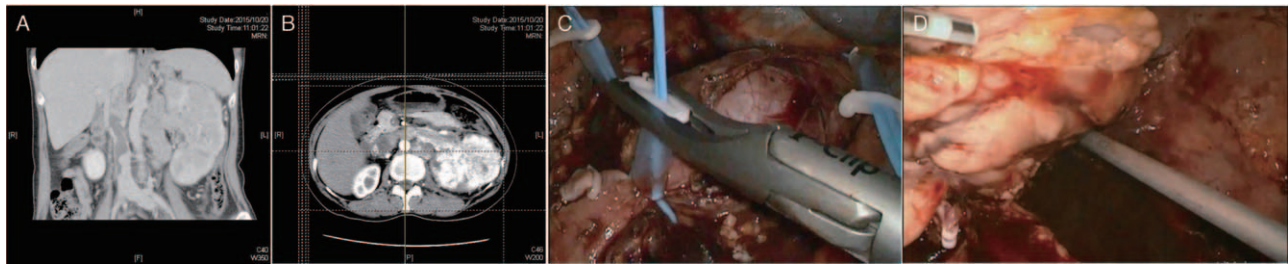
Plain computed tomography showing left kidney carcinoma with inferior vena caval thrombosis (A). The tumor and thrombus (coronal section; B). Isolating the vena cava and exposing the vena caval wall containing the thrombus (C). Removing the thrombus (D).
